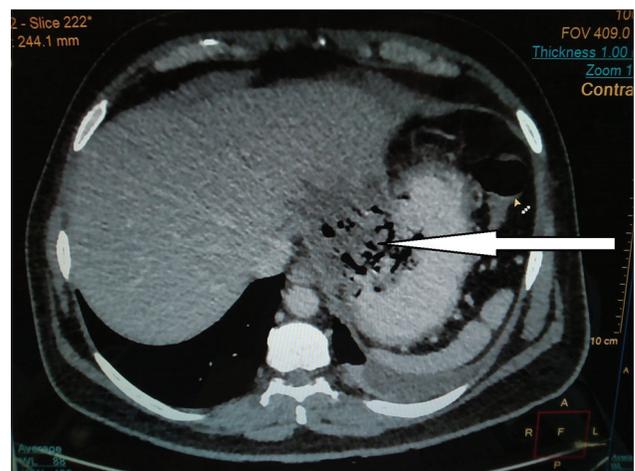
A contrast-enhanced computed tomographic scan of upper abdomen showing a heterogeneously hypodense lesion in the left lobe of liver with multiple air foci within, which are seen to extend into the body of stomach with small amount of surrounding fluid. The walls of fundus and lesser curvature are not well defined
